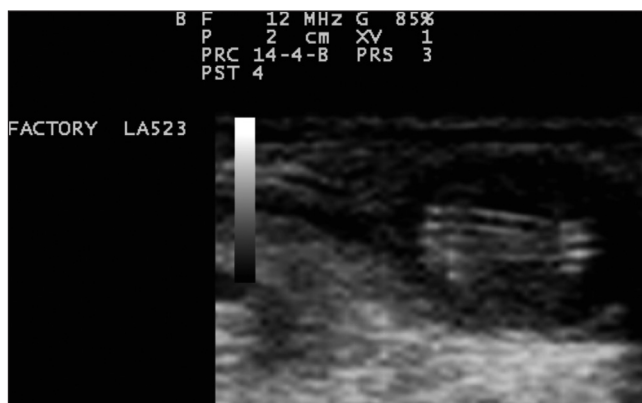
Ultrasound of a skin nodule showing the typical double linear parallel hyperechoic structures.
